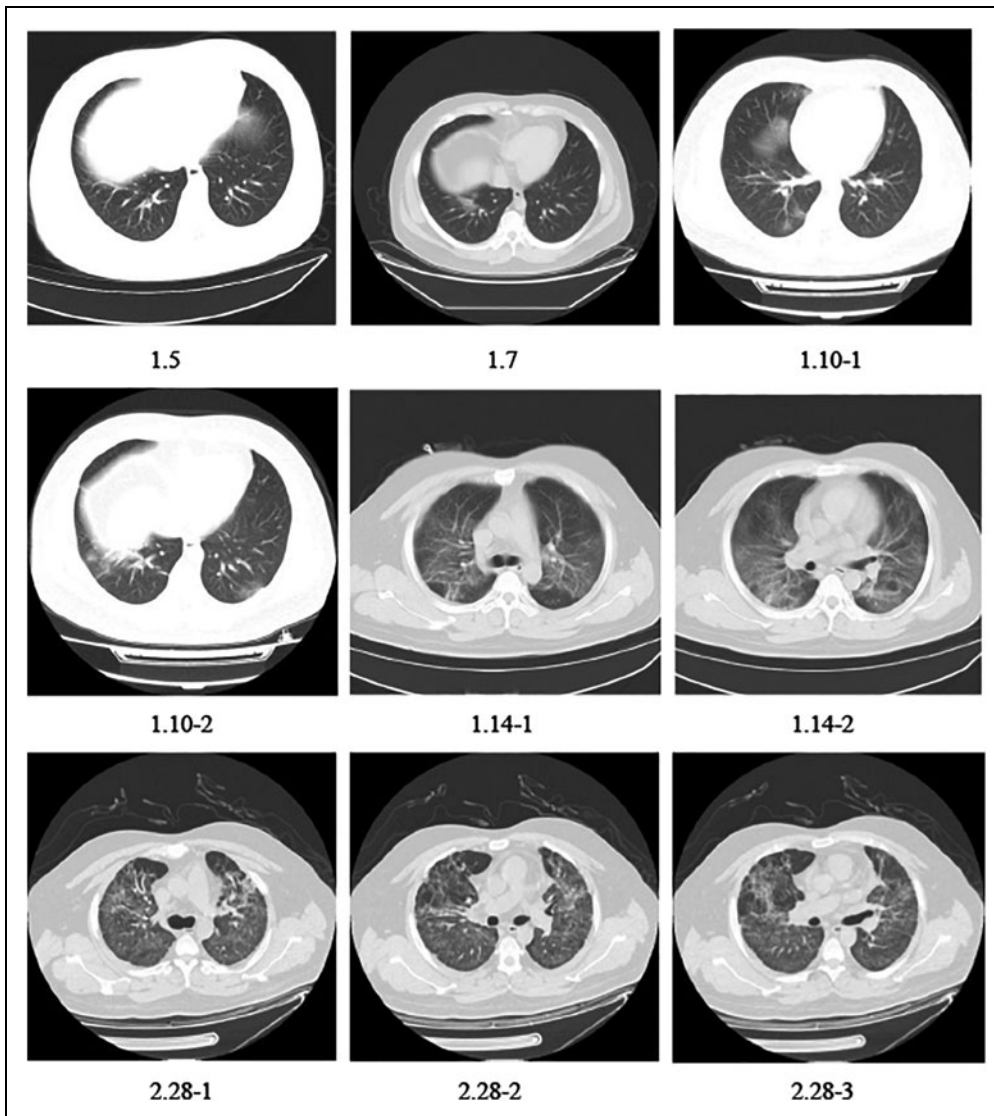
Changes in CT results of case 2.
